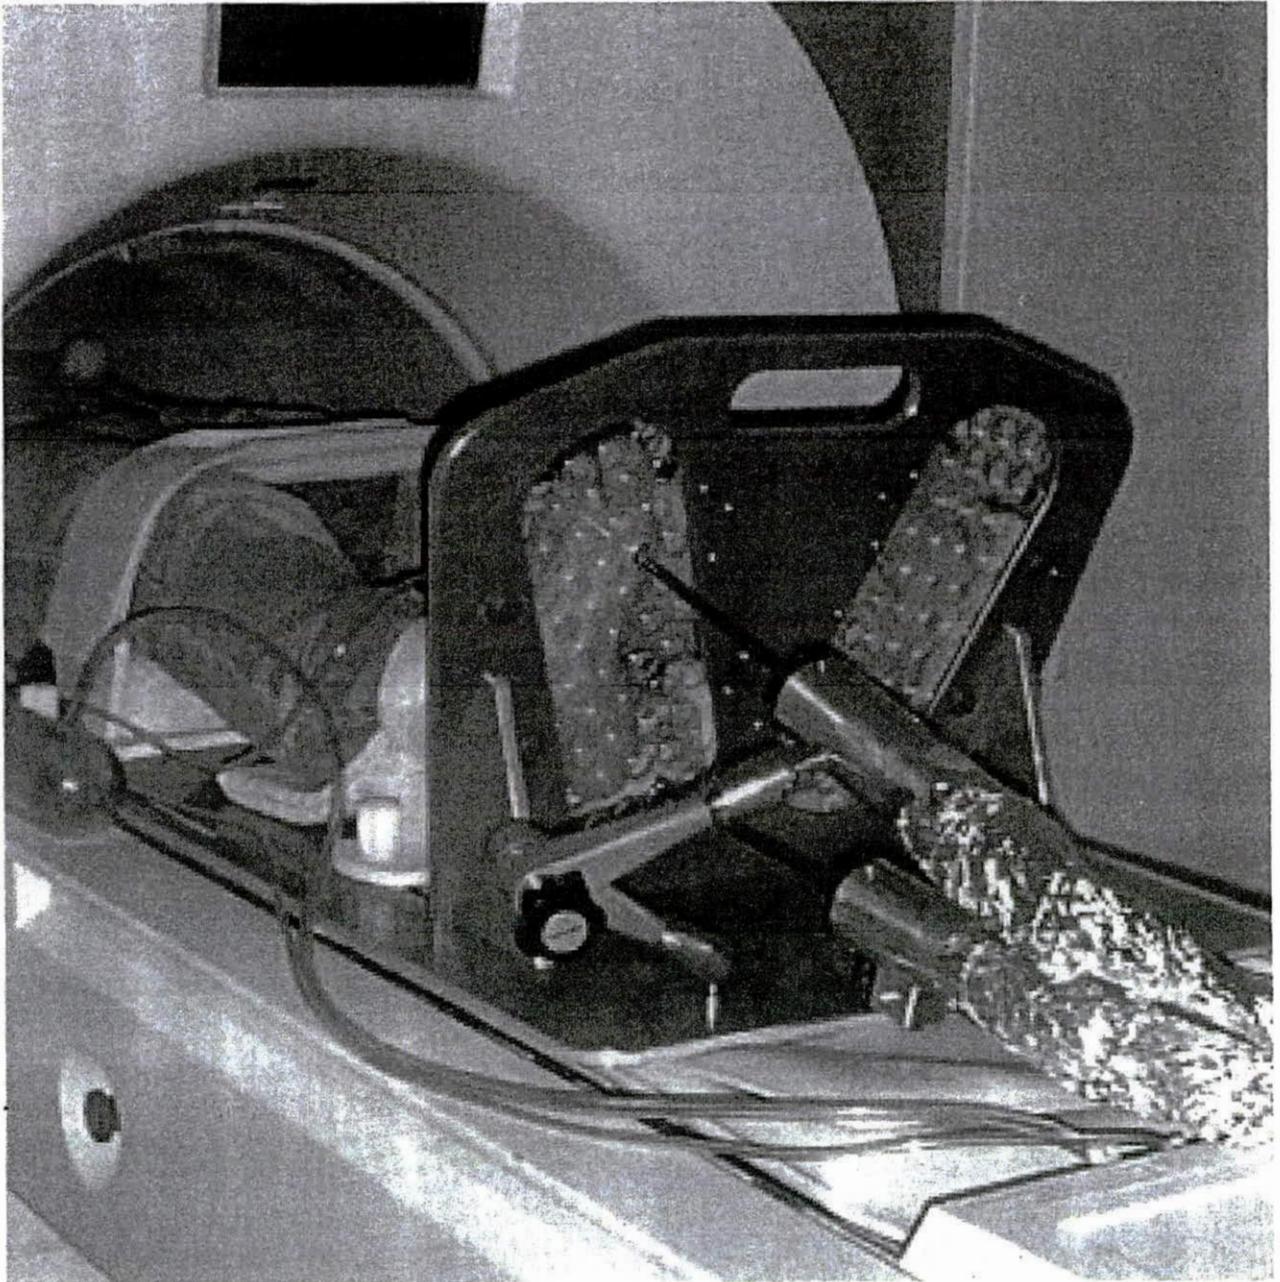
Moving Magnet Actuator System (MMAS) set up to work in the MRI environment
